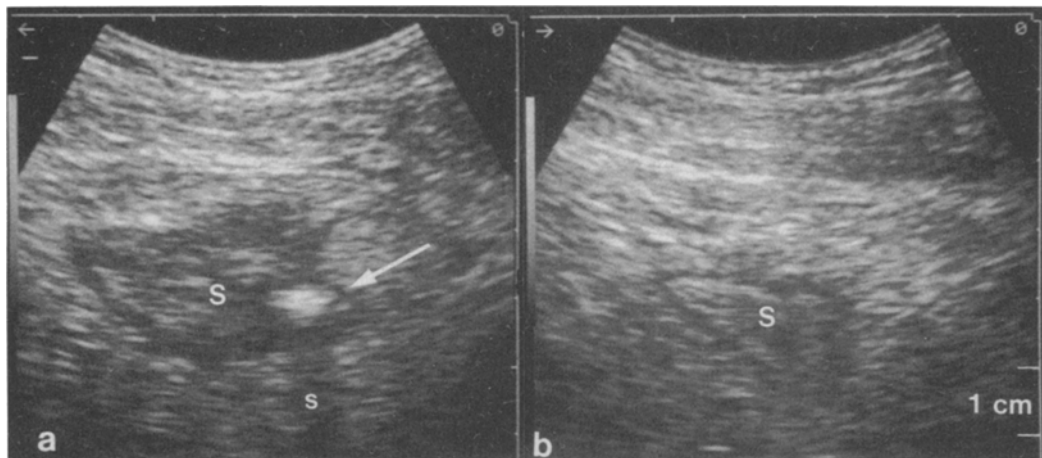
Ultrasound follow-up in sigmoid diverticulitis. a. Acute stage. Transverse scan of sigmoid colon (S) showing predominantly hypoechoic thickening of the bowel wall, luminal narrowing, and hyperechoic intramural diverticulum (arrow) with associated acoustic shadowing. b. Follow-up sonogram after medical treatment and resolution of diverticulitis. Lesser degree of wall thickening but still visible "target" appearance.
